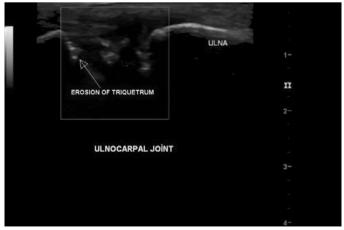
Ultrasonography of bone erosion at the ulnocarpal joint
